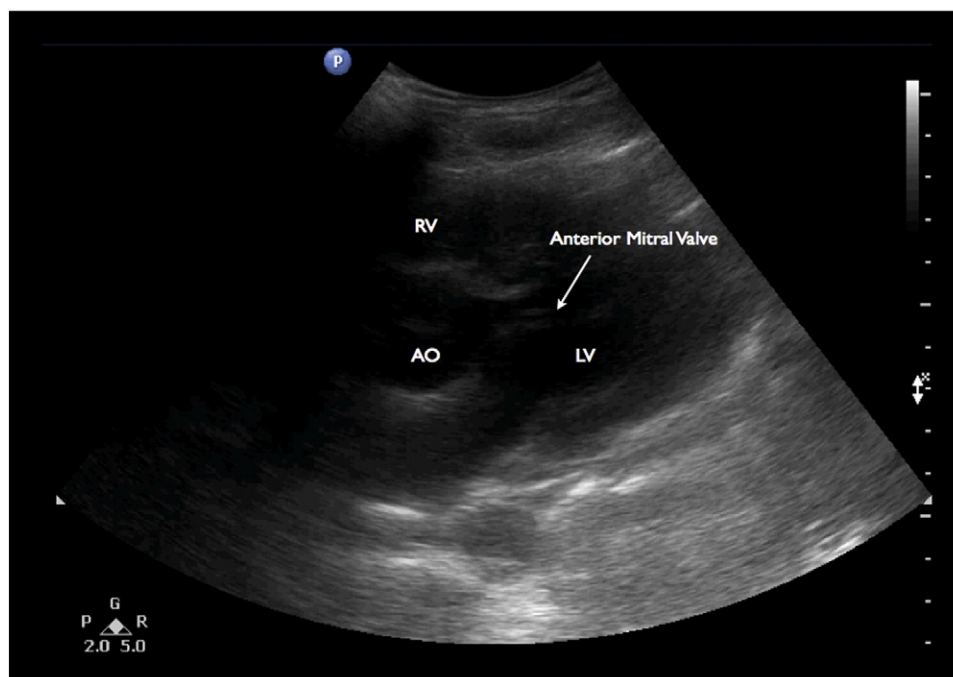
Bedside echocardiography/parasternal long view. RV indicates right ventricle; LV, left ventricle; AO, aorta. Cardiac cycle demonstrated a hyperdynamic heart with the anterior leaflets of the mitral valve striking the interventricular septum.
